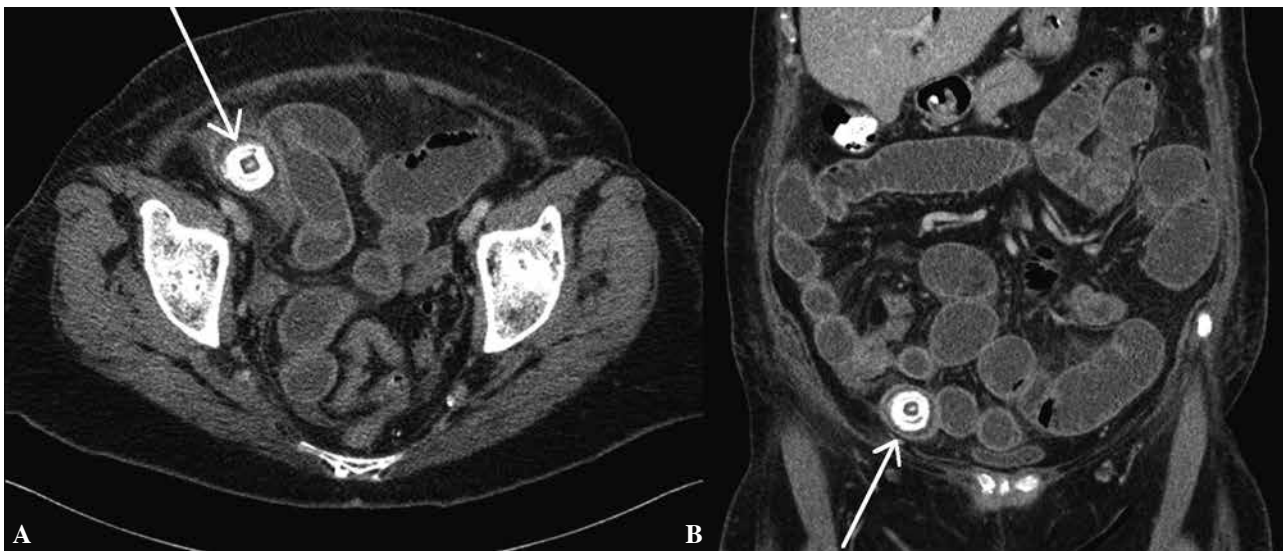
CT-scan, 14 days after initial surgery, demonstrating a second gallstone, 2.7 cm before Bauhin's valve. A. Transversal plane, B. Coronal plane.
